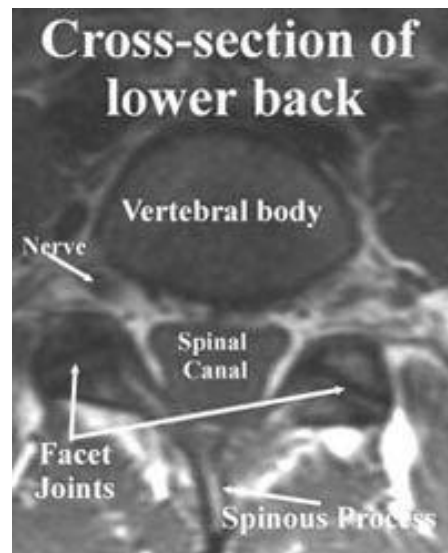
2 cross sectional view of spinal cord in Magnetic resonance imaging
